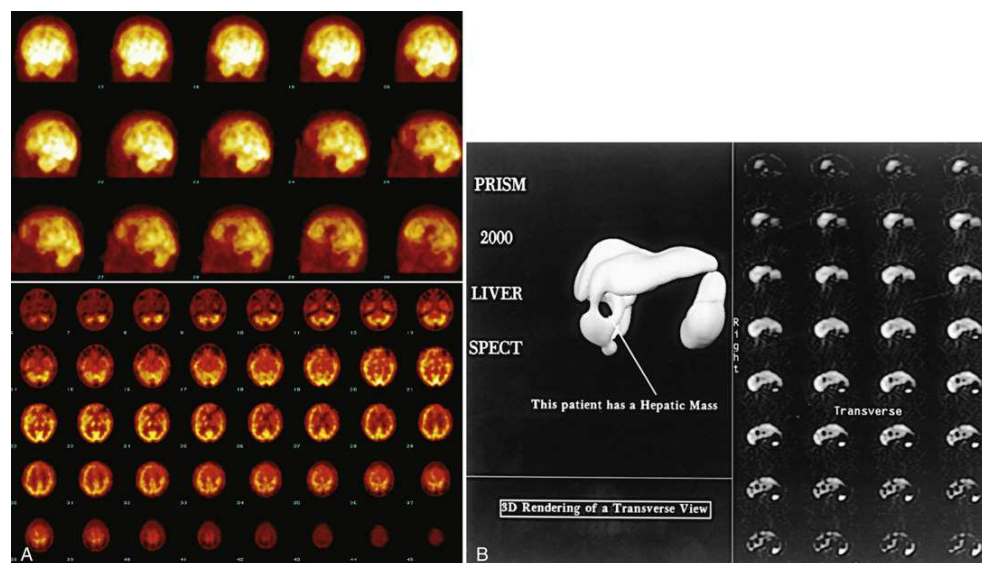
(A) Three-dimensional SPECT brain study using 20 mCi of ^{99m}Tc ethylcysteinate dimer showing a patient with a left frontal lobe brain infarct (*top*). Baseline and Diamox challenge transaxial, coronal, and sagittal images of the same patient, showing the left frontal lobe brain infarct (*bottom*). (B) Three-dimensional SPECT liver study using 8 mCi of ^{99m}Tc sulfur colloid. A mass is seen on the three-dimensional image (*left*) and transaxial images (*right*).
